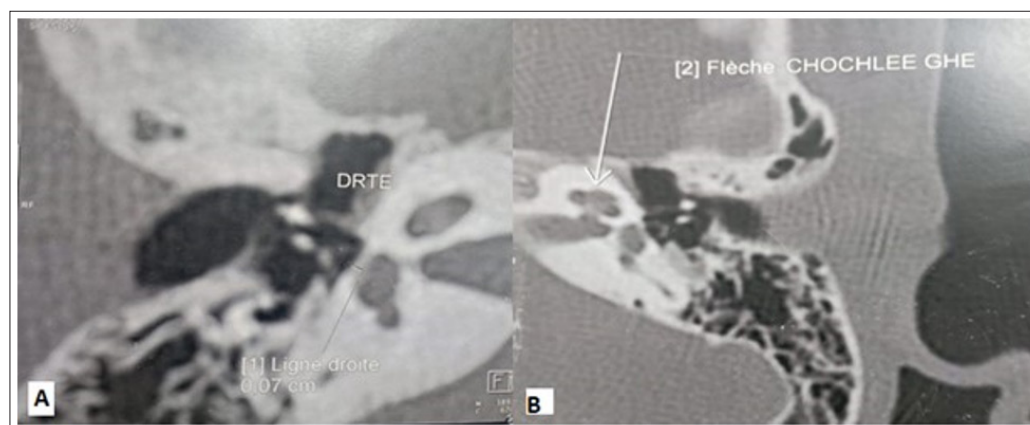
Axial view of Temporal bone CT of the right (A) and left ears (B) showing stage IA otosclerosis on the right A: The audiogram reveals a mixed hearing loss in the right ear, with a moderate to severe sensorineural component (bone conduction average of 55 dB) combined with a mild to moderate conductive component (air-bone gap of approximately 17 dB), B: Impedancemetric results showing middle ear pressure and compliance bilaterally, with preserved stapedial reflexes on the left but absent on the right.
